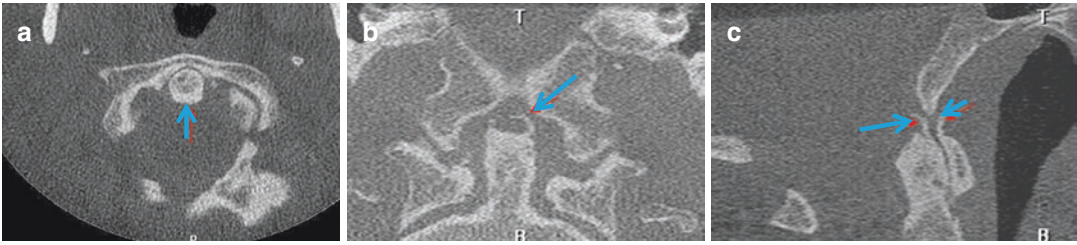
Axial (a), coronal (b), and midsagittal (c) CBCT images of a 76-year-old woman with severe OA in the region of C1 and C2 showing collapse of the odontoid process of C2 into the base, alar ligament calcification and calcification of the medial facets of C1
